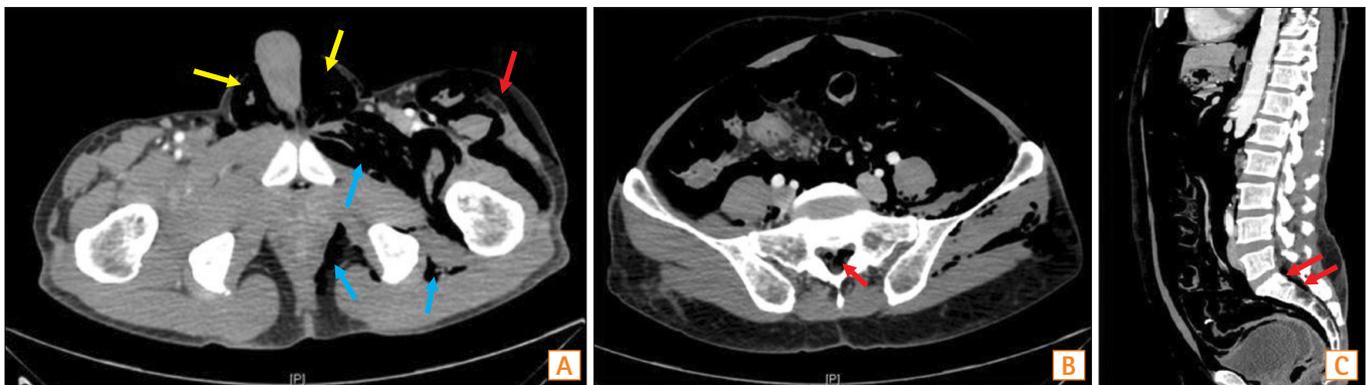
(A) CT of abdomen and pelvis showing air in scrotum (yellow arrows), pelvis subcutaneous (red arrow) and intramuscular emphysema (blue arrows). (B, C) CT scan showing air within spinal canal (red arrows) at level of sacral cauda equina.
